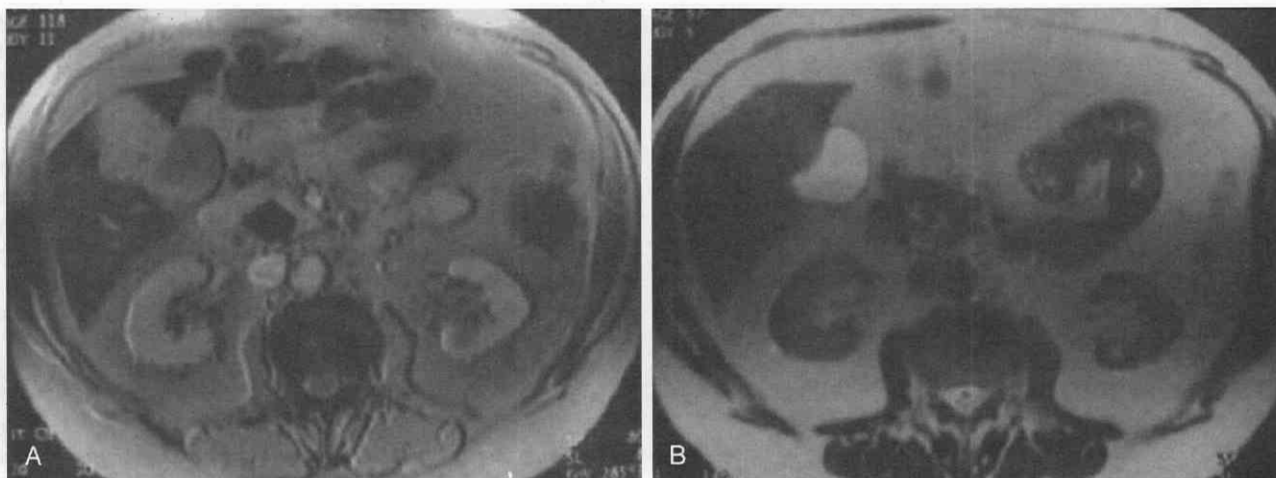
Hepatocellular carcinoma. A, Unenhanced T2-weighted image demonstrates a 3-cm lesion next to the gallbladder. B, T2-weighted image after superparamagnetic iron oxide (SPIO) administration demonstrates signal loss.
